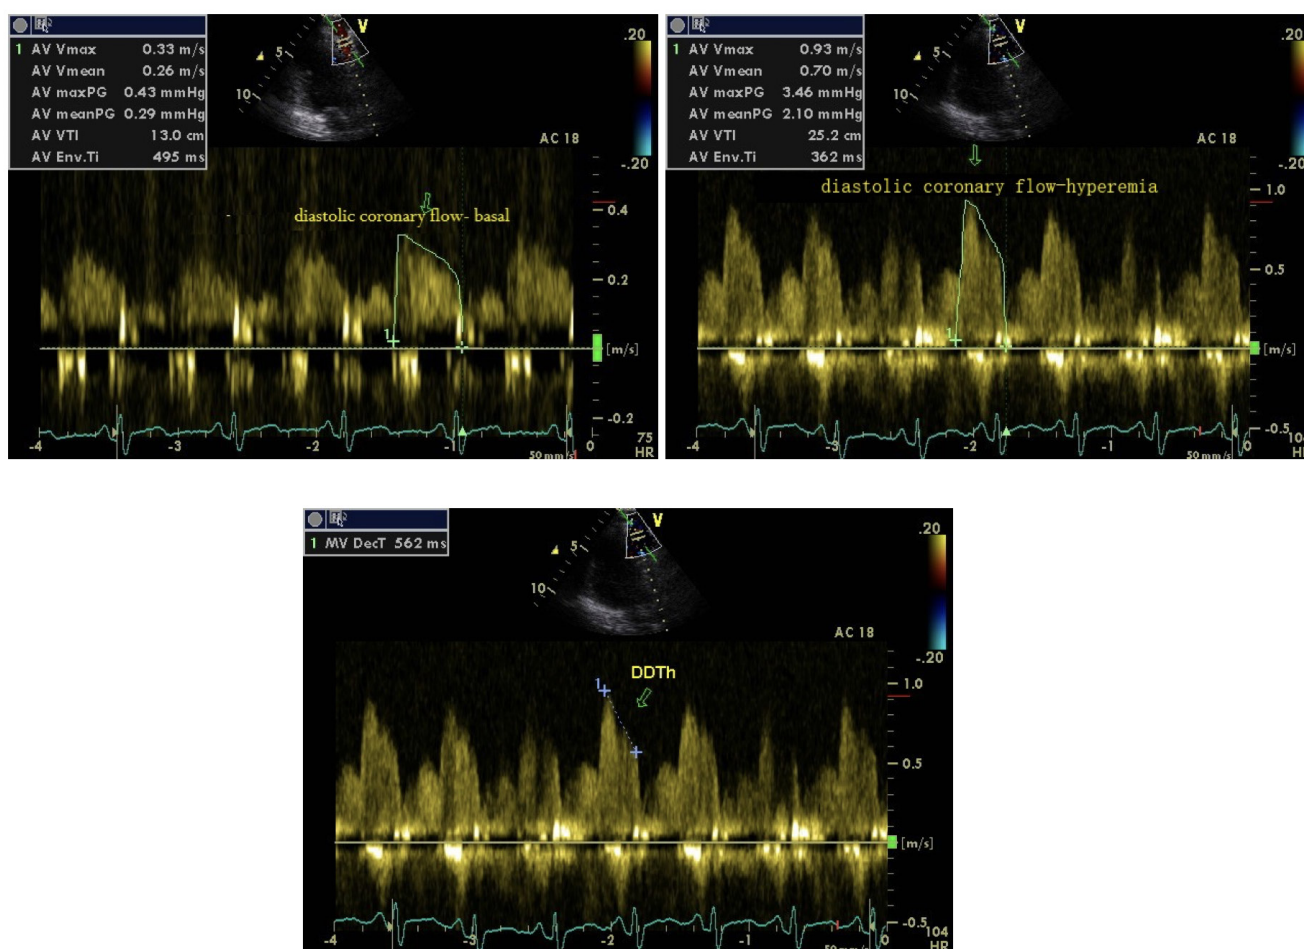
Hyperemic diastolic flow pattern, hyperemic diastolic deceleration time (DTh) and basal diastolic flow pattern obtained by pulsed wave doppler echocardiography from the mid-distal LAD in transthoracic echocardiography.
